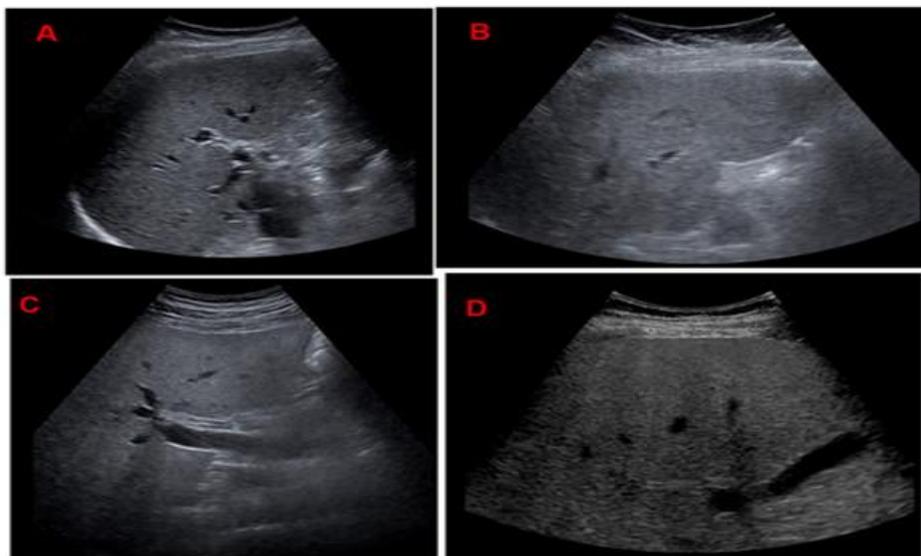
B-mode ultrasound transverse images of the liver are shown for four patients. The increased liver parenchyma echogenicity and decreased definition of intrahepatic structures such as vessel walls
